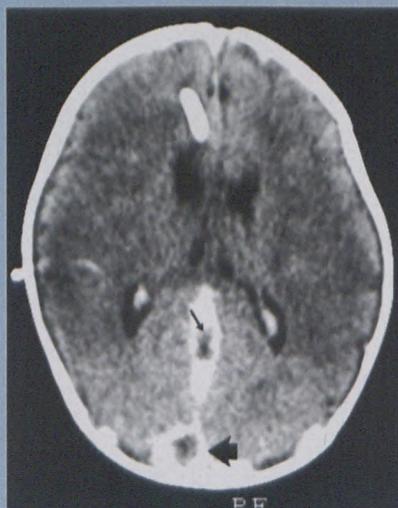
Post-contrast CT shows a 'delta' sign (large arrow) as well as a filling defect within the straight sinus (small arrow). The subcortical white matter is of low density bilaterally, in keeping with venous infarction.
